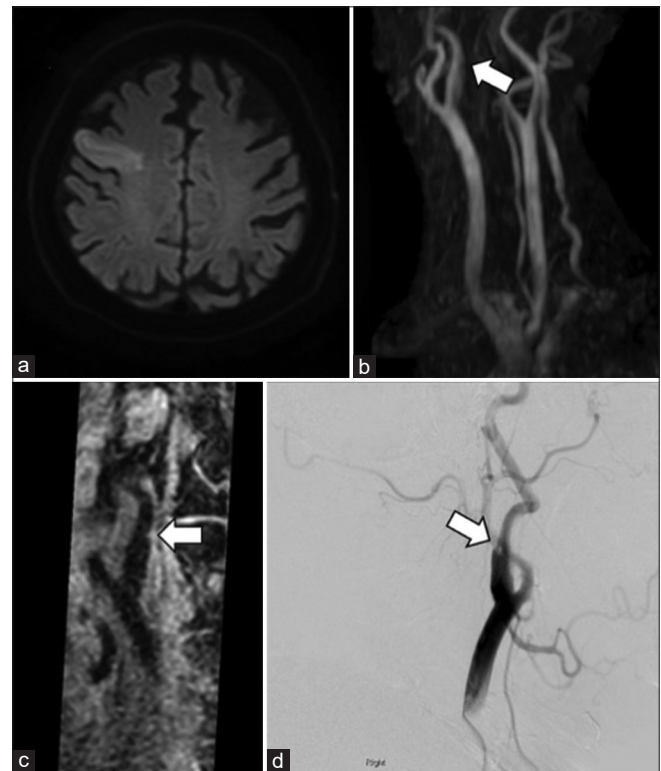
Images of a representative case. (a) MRI: Cerebral infarction of the right frontal lobe is observed; (b) MRA: A low-intensity linear structure protruding anteriorly from the posterior wall of the origin of the right internal carotid artery is observed (arrow). (c) T1 black-blood scan. Linear structures are visualized as slightly high-intensity lesions (arrow). (d) DSA. A linear shadow defect extending anteriorly from the posterior wall of the origin of the right internal carotid artery is observed (arrow).
